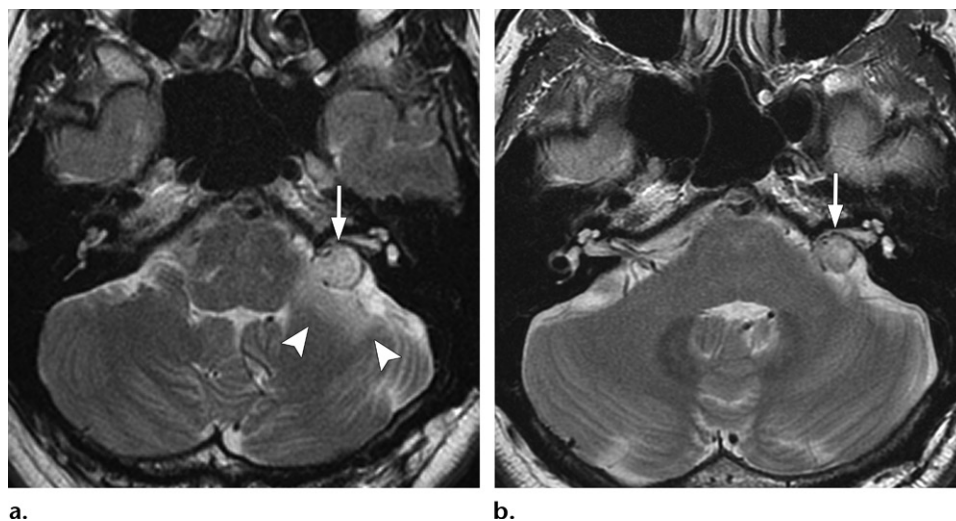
Peritumoral edema in a 43-year-old man who underwent stereotactic radiosurgery for a left vestibular schwannoma (arrow). (a) Axial T2-weighted MR image 1 month after stereotactic radiosurgery shows peritumoral edema (arrowheads) in the left middle cerebellar peduncle and cerebellar hemisphere. (b) Axial T2-weighted MR image 12 months after stereotactic radiosurgery shows spontaneous regression of the peritumoral edema.
